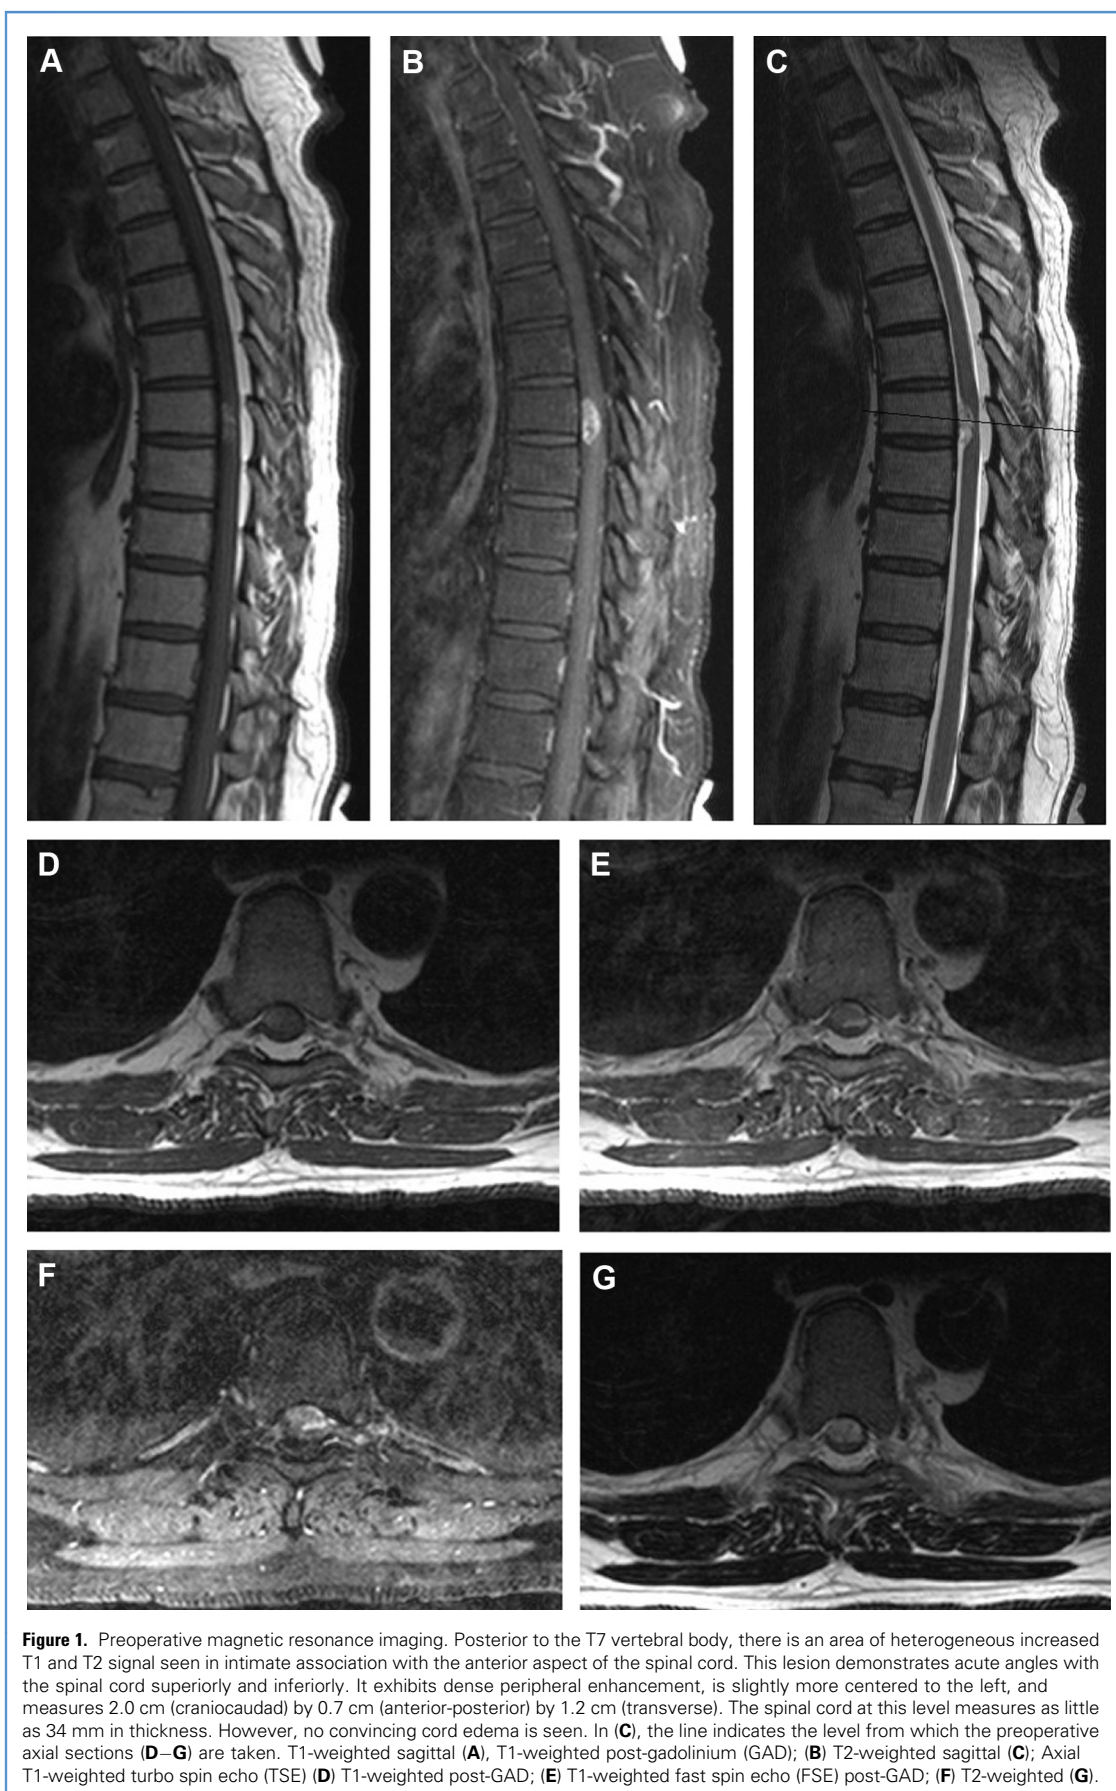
Preoperative magnetic resonance imaging. Posterior to the T7 vertebral body, there is an area of heterogeneous increased T1 and T2 signal seen in intimate association with the anterior aspect of the spinal cord. This lesion demonstrates acute angles with the spinal cord superiorly and inferiorly. It exhibits dense peripheral enhancement, is slightly more centered to the left, and measures 2.0 cm (craniocaudad) by 0.7 cm (anterior-posterior) by 1.2 cm (transverse). The spinal cord at this level measures as little as 34 mm in thickness. However, no convincing cord edema is seen. In (C), the line indicates the level from which the preoperative axial sections (D–G) are taken. T1-weighted sagittal (A), T1-weighted post-gadolinium (GAD); (B) T2-weighted sagittal (C); Axial T1-weighted turbo spin echo (TSE) (D) T1-weighted post-GAD; (E) T1-weighted fast spin echo (FSE) post-GAD; (F) T2-weighted (G).
